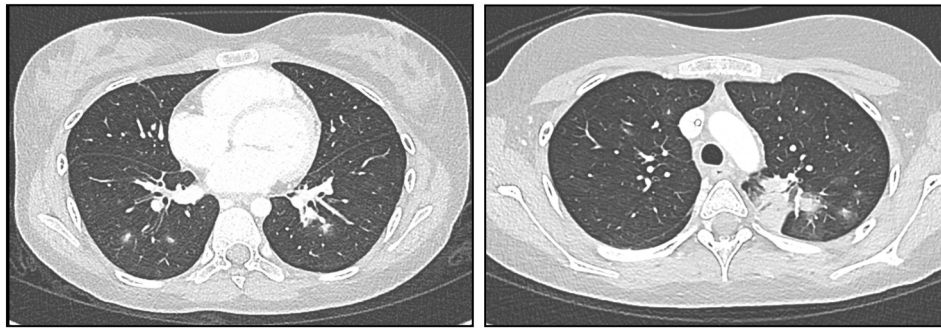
Initial chest CT findings. Axial images performed at clinical deterioration demonstrate multiple millimetric parenchymal nodular thickenings with peripheral ground-glass opacities.
